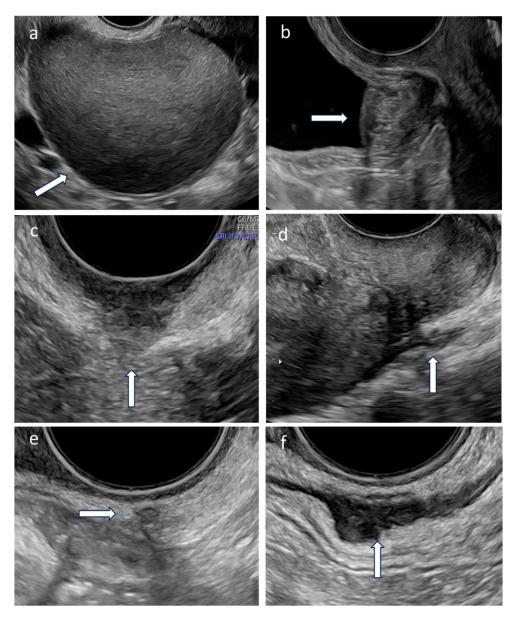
Ultrasonographic findings of endometriosis in different locations Endometriosis lesions in the particular anatomic location are indicated by the arrow. a) Endometrioma, b) urinary bladder, c) vaginal wall, d) uterosacral ligament, e) rectovaginal septum, f) bowel wall
